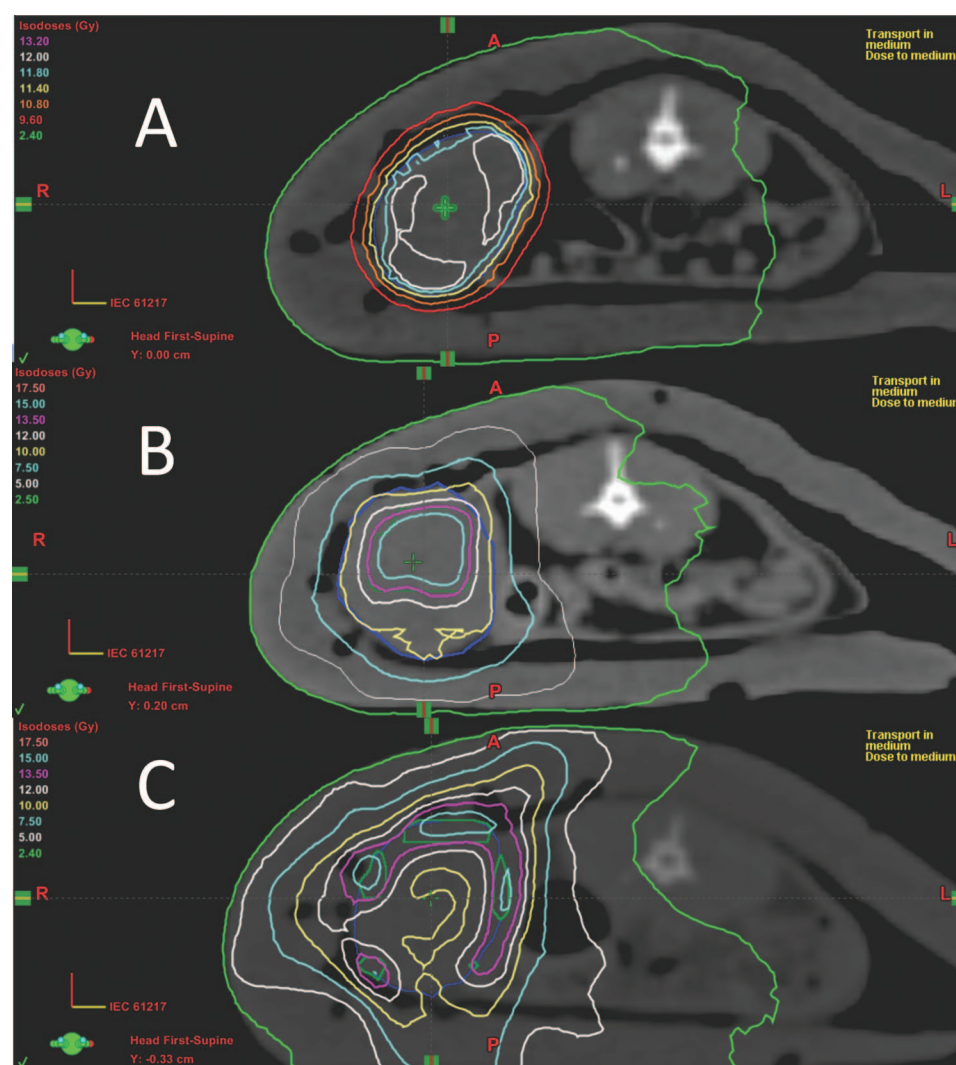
Representative treatment plans for the three different arms of the study. Panel A: Dose distribution for a uniform plan (arm A) with a mean dose of 12 Gy prescribed to the GTV. Panel B: Dose distribution for an FDG high-uptake boost plan (BTV_{high}; arm B) with a prescribed dose of 15 Gy to 30% of the GTV with the highest FDG uptake. Panel C: Dose distribution for an FDG low-uptake boost plan (BTV_{low}; arm C) with a prescribed dose of 15 Gy to 30% of the GTV with the lowest FDG uptake.
